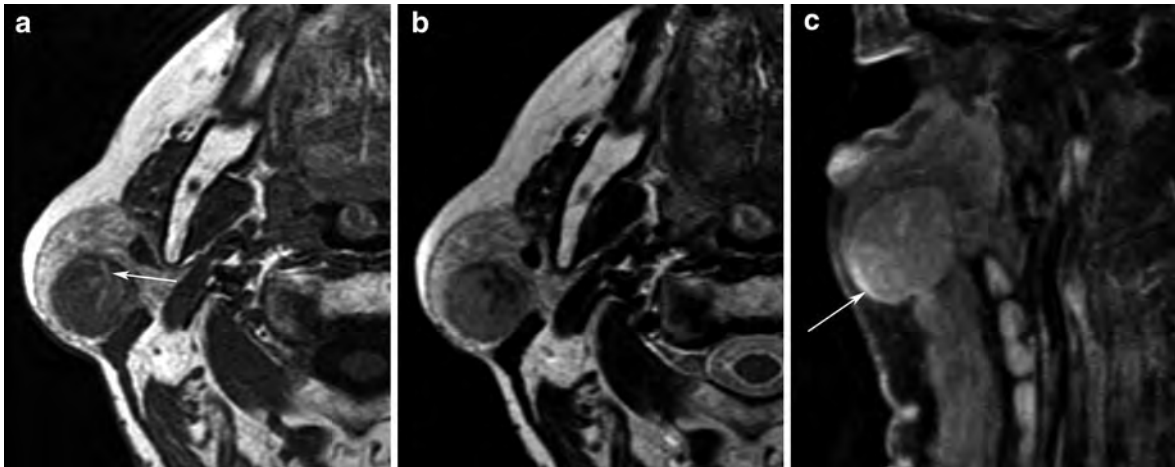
Typical Warthin tumor in the superficial lobe of the right parotid gland showing a low T1-weighted signal intensity with small high-signal intensity areas (arrow, a), a low
